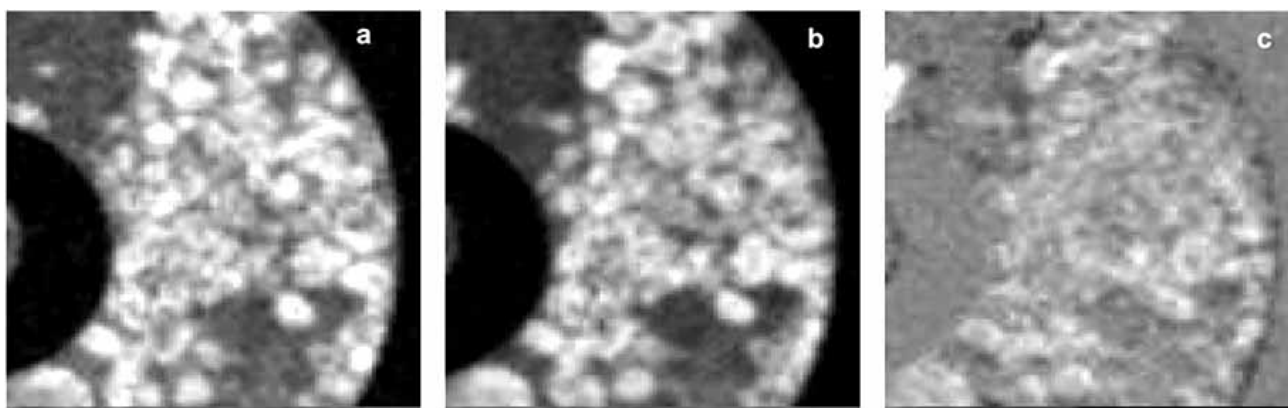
Manganese induced MRI signal enhancement in perfused isolated human islets. a) Spin echo image of human islets in a MR perfusion chamber following perfusion with Krebs-Ringer Buffer supplemented with 2mM glucose and 50µM MnCl₂; b) following perfusion with Krebs-Ringer Buffer supplemented with 16mM glucose and 50µM MnCl₂; c) subtraction image (b-a) showing showing signal enhancement due to glucose activation induced Mn uptake. Acquisition parameters: TR/TE = 400/7.8 ms, matrix = 128x128, FOV = 0.45 cm, slice thickness = 0.3 mm, in-plane resolution = 40 µm, NEX = 20. Temperature= 35°C.
